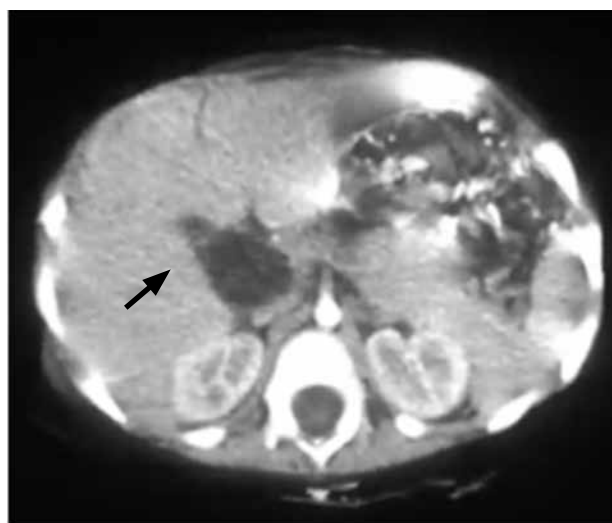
Contrast computed tomography (CT) of abdomen. Arrow: cyst.
